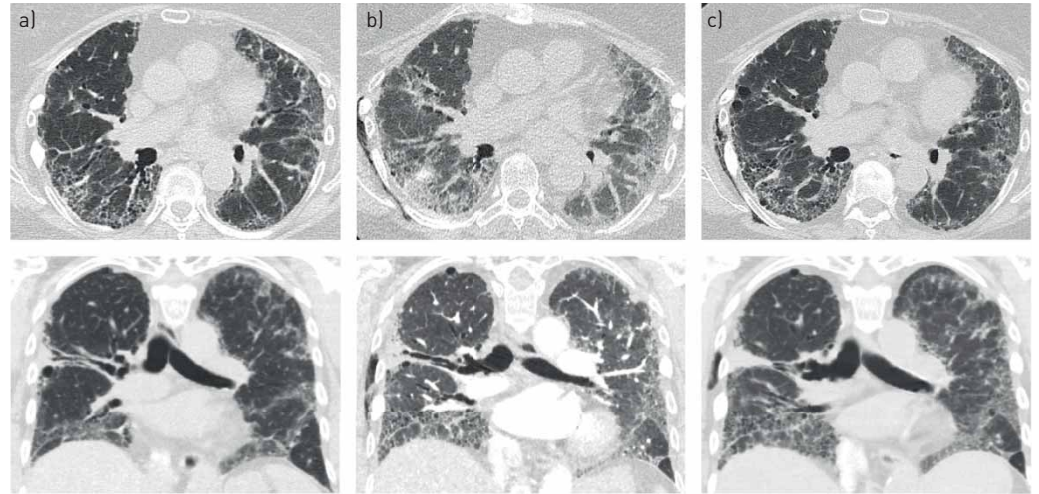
A 63-year-old woman with rheumatoid arthritis-associated interstitial lung disease who presented to clinic with 2 weeks of increasing shortness of breath. Axial and coronal images show a) baseline computed tomography 1 year before presentation showing reticulation and honeycombing in a definite usual interstitial pneumonia pattern; b) presentation of acute exacerbation of interstitial lung disease with new onset bilateral ground-glass opacities on background of usual interstitial pneumonia and c) follow-up computed tomography 1 week after treatment with high-dose steroids showing some improvement in ground-glass opacification.
